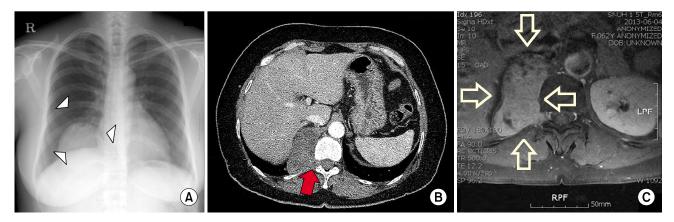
Image studies from the first and second surgeries. (A) Chest radiogram prior to the first surgery that shows a mediastinal mass (white arrow head). (B) Thirteen years later, a computed tomography scan detected a posterior mediastinal mass (red arrow). (C) A magnetic resonance image reveals a solid mass that originated from the 11th intercostal nerve (white empty arrow).
